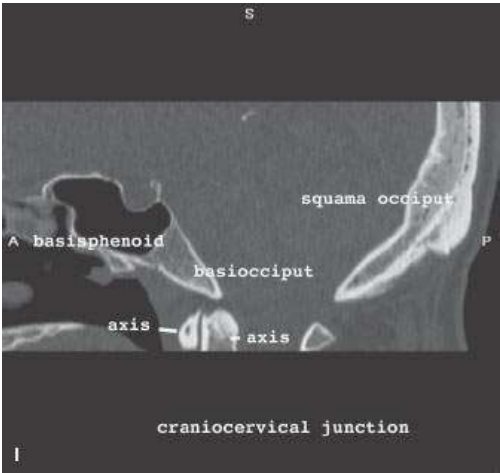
Posterior skull base. A–F: Normal anatomy of the posterior skull base is shown on consecutive axial computed tomography images. G–I: The clivus is formed by the basisphenoid and basiocciput, as shown on these sagittal images. The spheno-occipital fissure or synchondrosis is well seen in children, as in the 4 year old in (G) and the teenager in (H), but will be ossified in adults (I).
